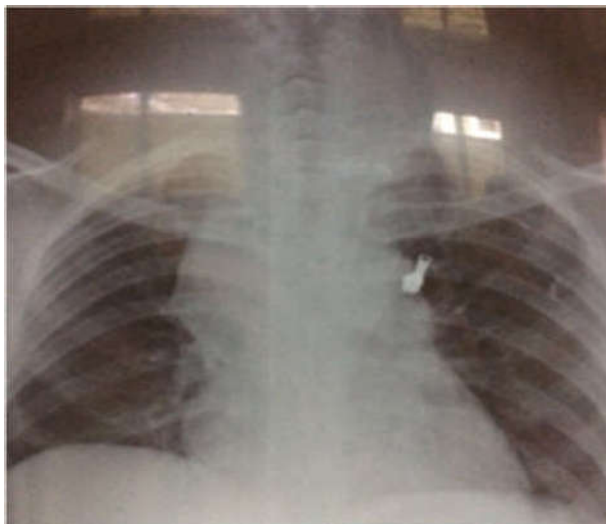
Chest radiograph showing mediastinal tumor causing tracheal compression
